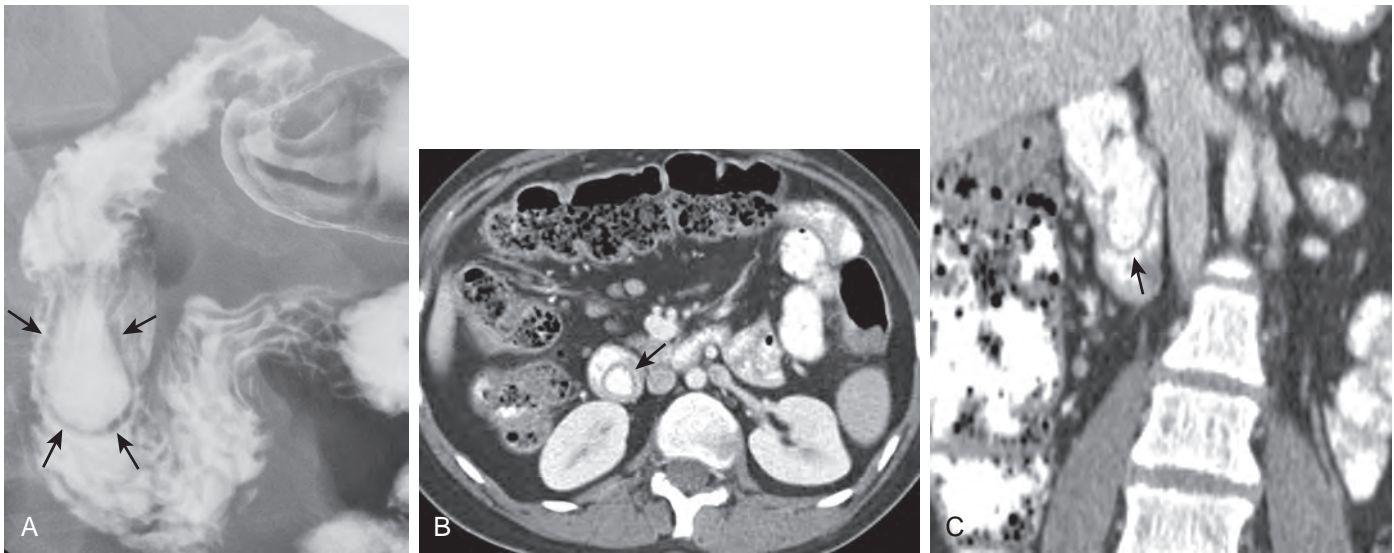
Intraluminal duodenal diverticulum. A. The finger-like, barium-filled sac in the descending duodenum is separated from barium in the adjacent lumen by a radiolucent band (arrows) representing the wall of the diverticulum. B and C. Axial (B) and coronal (C) CT scans also show the barium-filled intraluminal sac separated from barium in the adjacent duodenal lumen by a thin lower density web (arrows).
